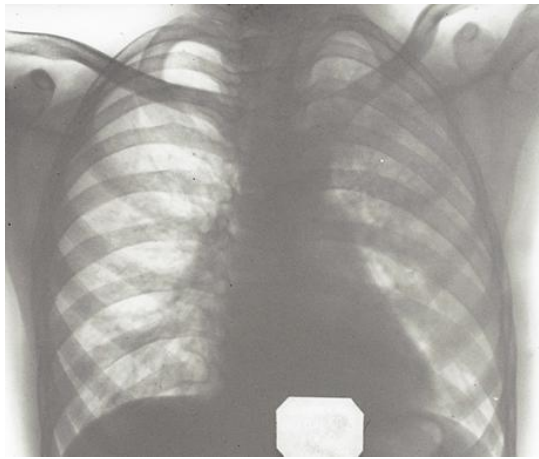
Plain chest X-ray of a child with left lung contusion due to blunt thoracic trauma (motor vehicle accident). Cloud-like opacification of the left lung is sharp boundaries
